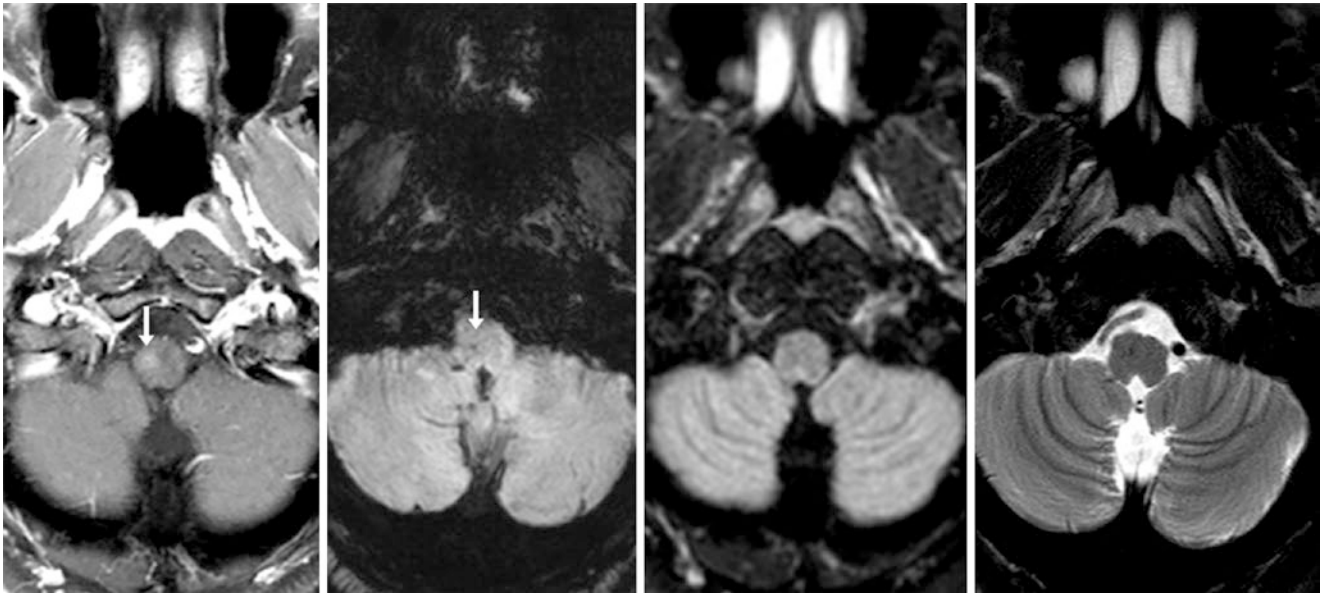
A 55 year old with hyperesthesias had faint enhancement of a medullary *BCT* (arrows) on 1.5T MRI postcontrast axial SE T1WI (left), with faint low signal on SWI (left middle). The *BCT* is invisible
